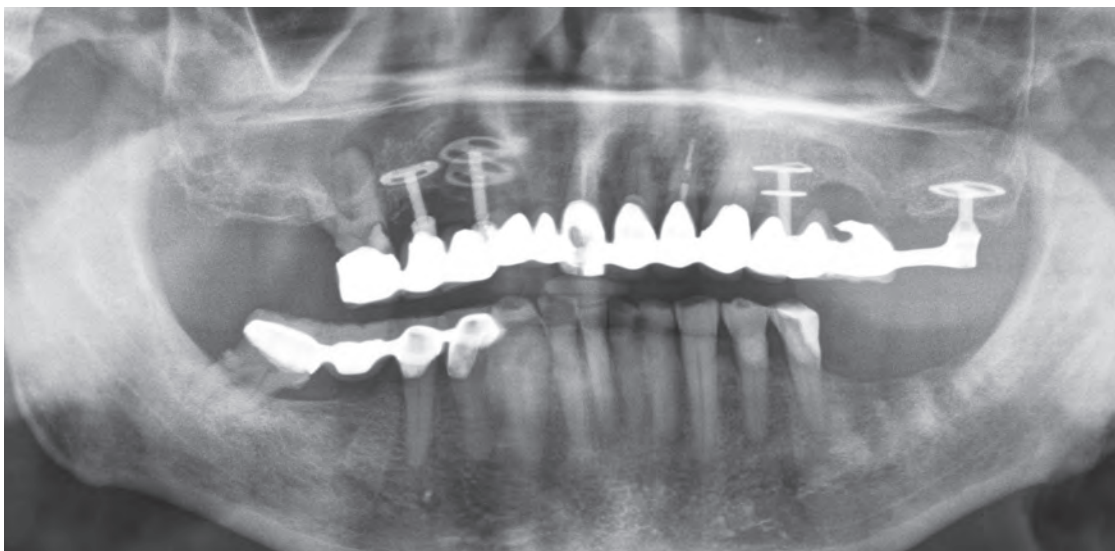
Panoramic radiograph taken in 2026 before the corrective intervention. After removal of all ailing teeth, the upper jaw contained only four (out of the original five) lateral basal implants (BOI®). All implants appeared 100% stable with no signs of periimplantitis or bone loss.
